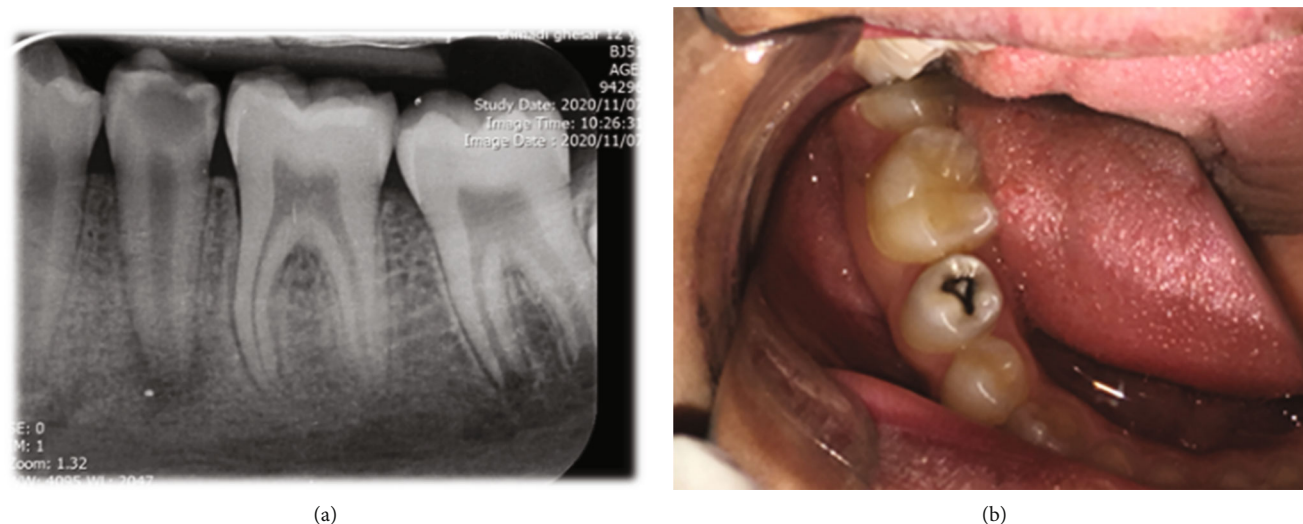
(a) The initial periapical radiograph showing prominent tubercles due to dens evaginatus, periapical radiolucency, and deep caries in tooth #20 with an immature apex; (b) preoperative photograph and caries in tooth #20; the intact tubercle can be observed on the occlusal surface of this tooth.
